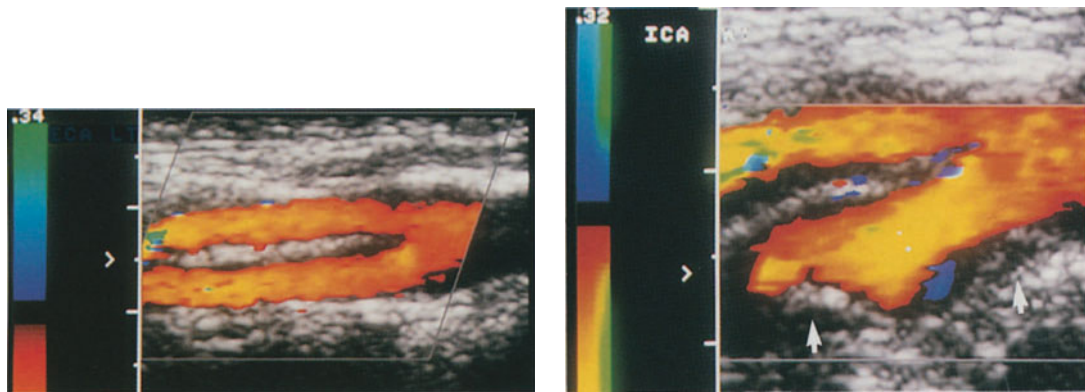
(left) Longitudinal sonogram of carotid bifurcation and proximal portions of ICA and ECA shows normal morphologic and hemodynamic appearance. However, no bulb formation is identified in the CCA or ICA
